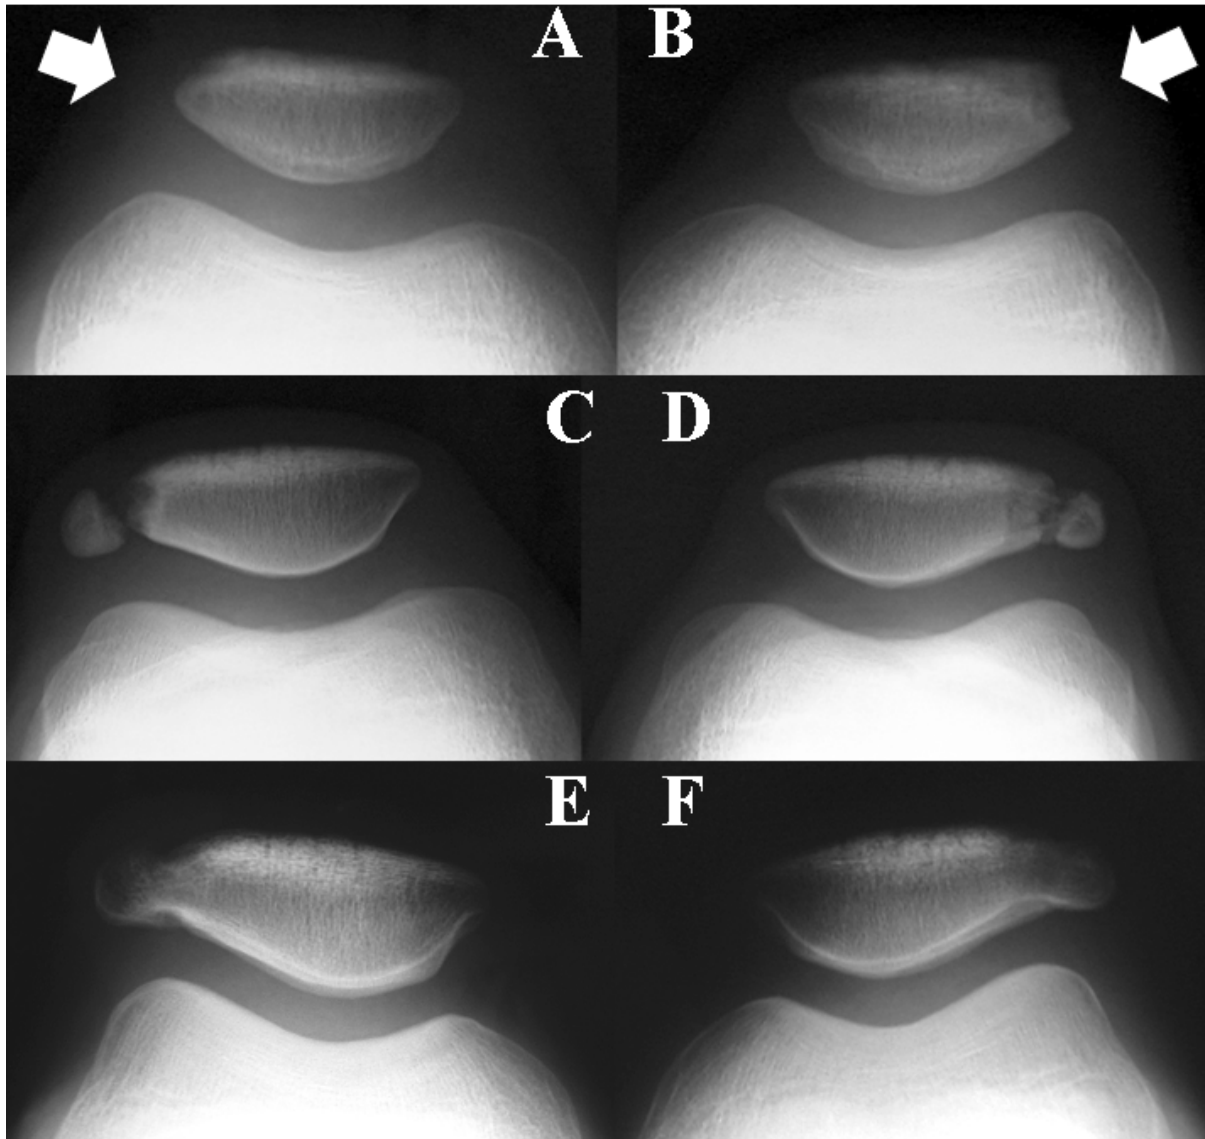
Radiography of Case 1 along with time course. A, C, E) Right knee. B, D, F) Left knee. A, B) Radiography at the time of initial complaint of pain in both knees at 11 years old. The shape of the right patella seemed normal (A), but the lateral edge of the left knee seemed deficient (B). C, D) Preoperative radiography at 12 years old. Both knees displayed bipartite patella (Saupe classification, type II). E) Right knee at 4 months postoperatively. F) Left knee at 2 months postoperatively. Bone union seemed complete.
